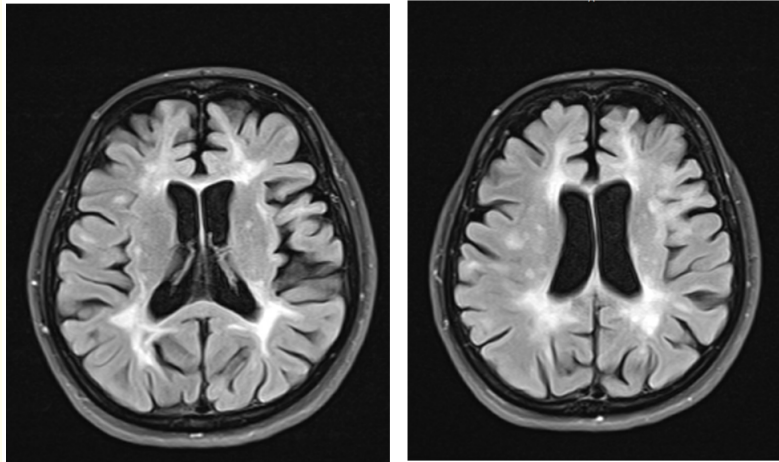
MRI T2 FLAIR sequence demonstrating multiple enhanced and non enhanced periventricular and Juxtacortical lesions suggestive of demyelinating disease.
